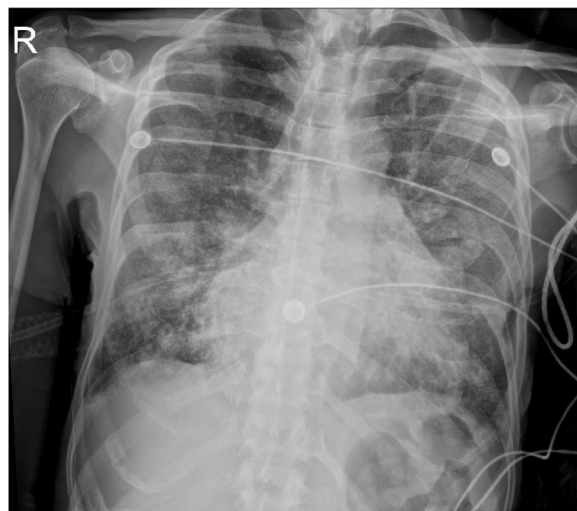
Chest radiograph on admission, showing enlarged cardiac silhouette and bilateral patchy opacities.
